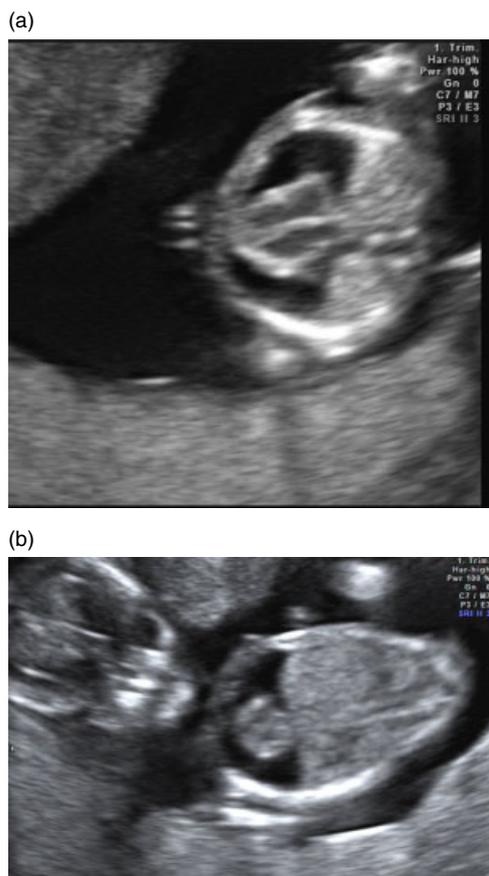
(a-b)—Ultrasound at 11 weeks with the pericardial effusion (PE)
